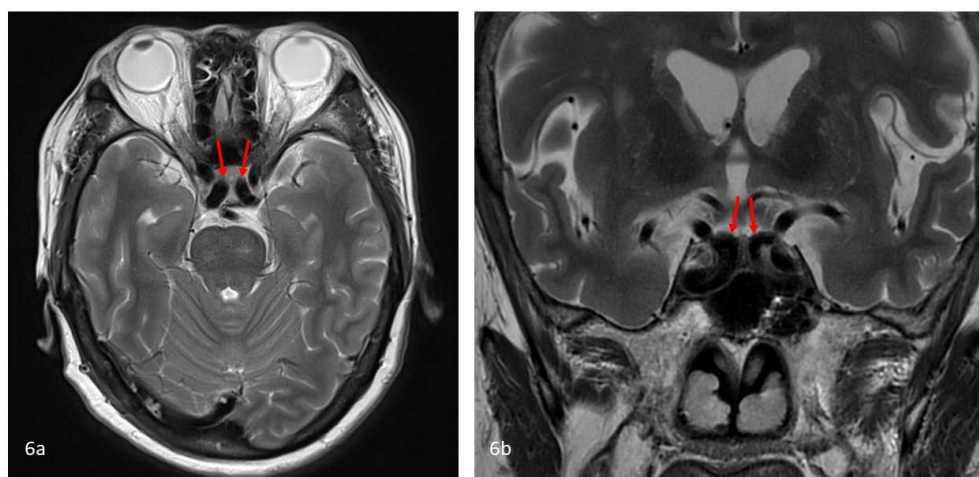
Kissing carotids sign. 75 year old female with bilateral tortuous cavernous internal carotid arteries. Axial (6a) and coronal (6b) T2-weighted MR images of the brain showing tortuous bilateral cavernous carotid arteries which deviated into the sella approximating each other (red arrows), suggestive of intra-sellar “kissing carotids”. Axial: Siemens Magnetom Skyra, 3.0 Tesla, Slice width 4.0 mm T2-weighted sequence, TR 5460 TE 92 FA 90; Coronal: Siemens Magnetom Aera, 1.5 Tesla, Slice width 2.5 mm, T2-weighted sequence, TR 2950 TE 112 FA 150.
